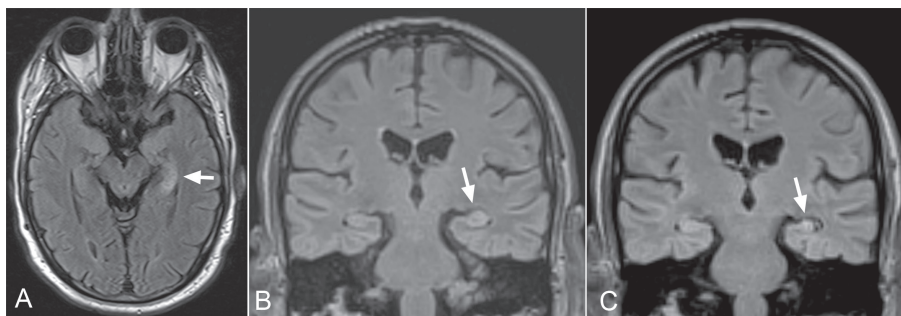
Patient with hippocampal injury (patient 1). In the first examination, the left hippocampus (arrow) is oedematous: it is enlarged and shows high T2 signal intensity. (A) Axial and (B) coronal slices with a fluid attenuated inversion recovery (FLAIR) sequence. (C) In the second examination, the left hippocampus is shrunken and has a high T2 signal intensity.
